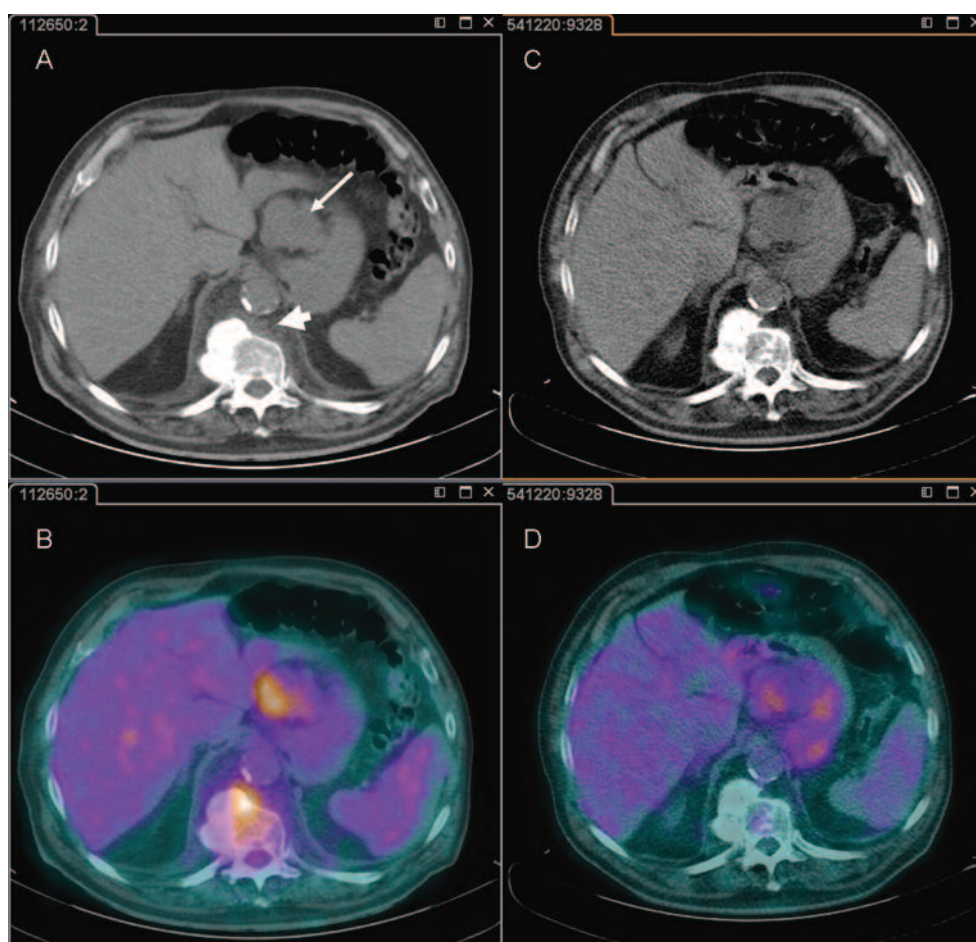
Transaxial CT (A,C) and Fluorine 18-fluorodeoxyglucose (FDG) PET/CT (B, D) images in a 50 year-old female patient with concomitant gastrointestinal stromal tumor (*arrow head*) and spondylodiscitis (*arrow*). There was an increased unspecific uptake of FDG both in tumor and in inflammatory lesion at diagnosis (A, B). After anti-neoplastic therapy with Imatinib and antibiotic therapy both lesions showed a decrease of FDG uptake (C, D), demonstrating a good metabolic treatment response.
